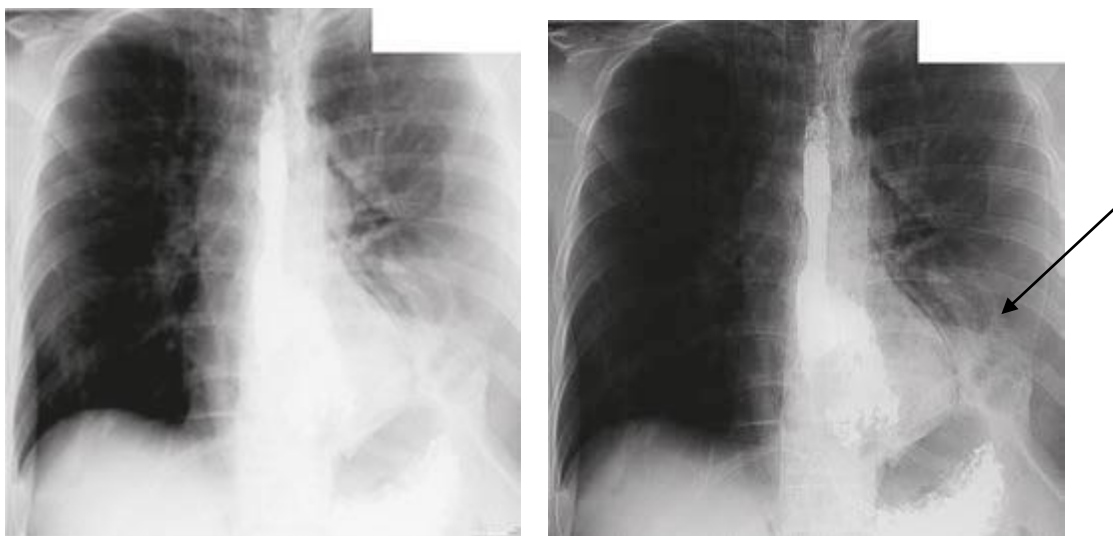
X-ray scan of the chest, X-ray contrast study of the esophagus. The arrow indicates the rupture of the left wall of the esophagus with the tracer leakage.
